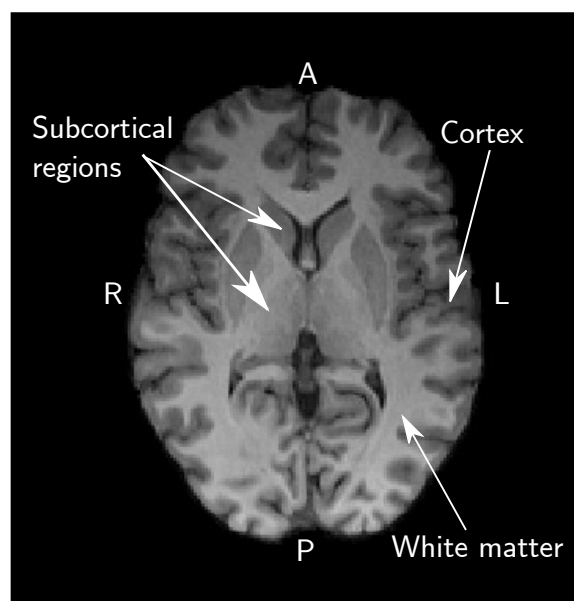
The brain. A structural MRI image from a representative subject. R=right; L=left; A=anterior; P=posterior
